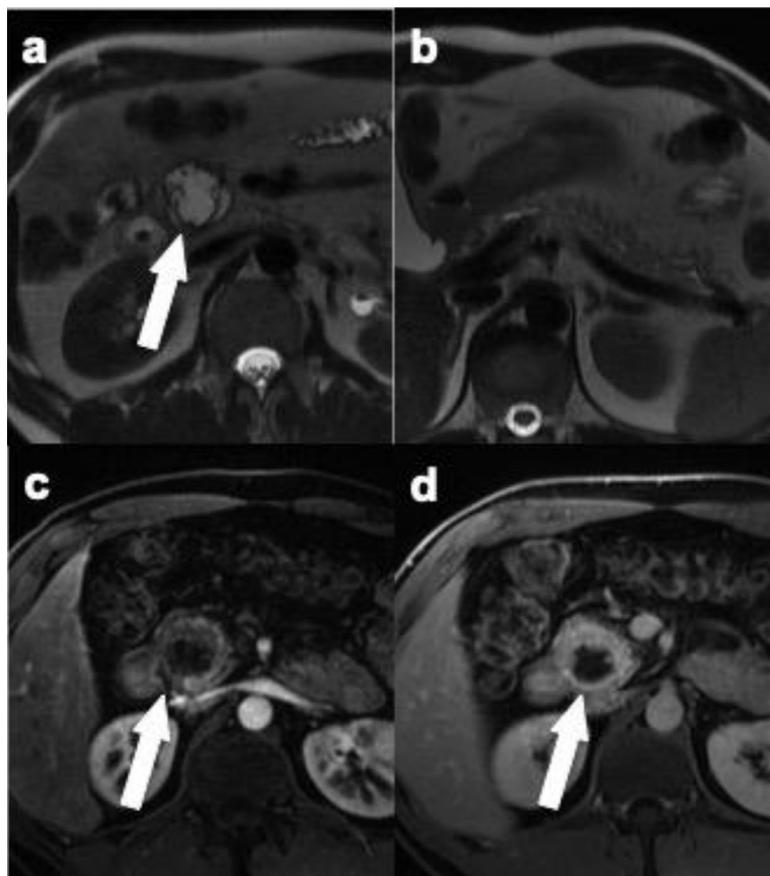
Colloid pancreatic adenocarcinoma in a 36 year-old male. Axial T2-weighted single-shot MR images (a, b) show a lesion (arrow) located in the pancreatic head, presenting with a heterogeneous bright signal, without upstream ductal dilatation (b). The lesion shows heterogeneous enhancement on a fat-suppressed T1-weighted GRE MR image obtained during the arterial phase (c) with progressive appearance during the late venous phase (d). Colloid adenocarcinoma was confirmed after resection.
